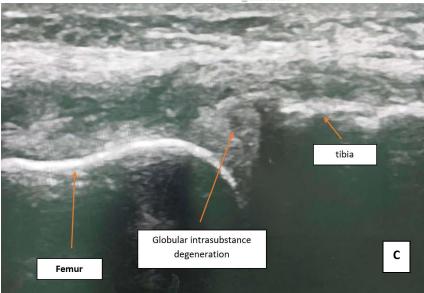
A 47-year-old male patient comes with left knee pain and click. MRI exam: (a) sagittal T2WI and PDWI Showing abnormal signal intensity within posterior horn of medial meniscus not reaching to articular surface denoting degeneration. (b) sagittal STIR Showing bone marrow edema. Ultrasonography: Fig (c) Showing irregularities and intra substance area of fluid filled (degeneration) seen within medial meniscus.
